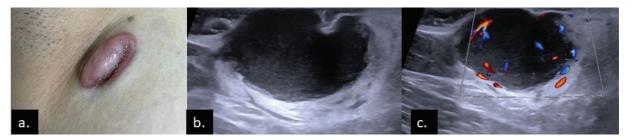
A 17-year-old girl presented with a right breast reddish dermal lesion (a), which was progressively increasing in size. (b and c) Ultrasound showed a necrotic mass with hyperechoic rim in the skin and subcutaneous tissue with marked internal vascularity. Normal looking nodes were seen in the right axilla (not shown). Biopsy revealed dermatofibrosarcoma protuberans and the patient subsequently underwent surgery.
